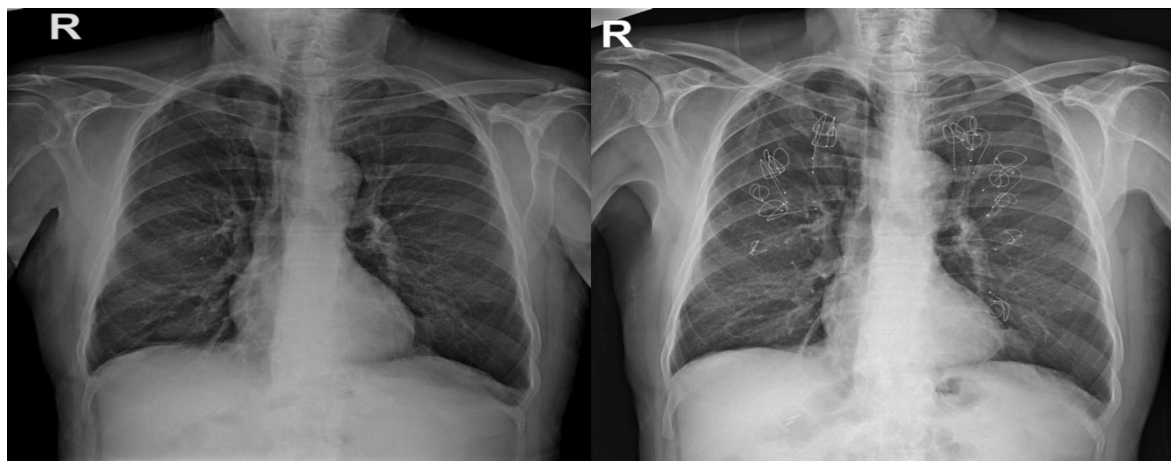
Postero-anterior radiography of the patient with bilateral coil
